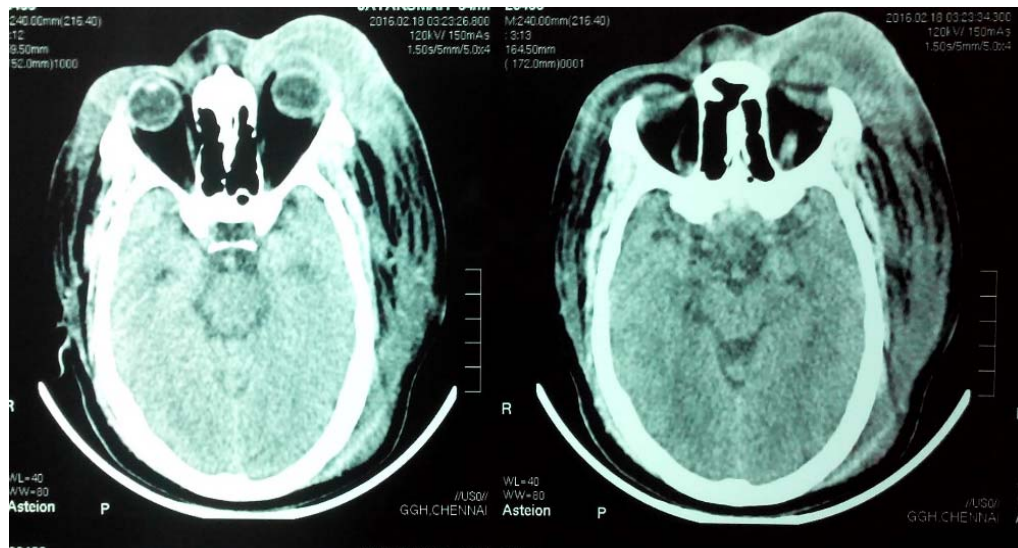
CT orbit Axial view with hyperintense lesion in the intra and extraconal area with fat infiltration.
